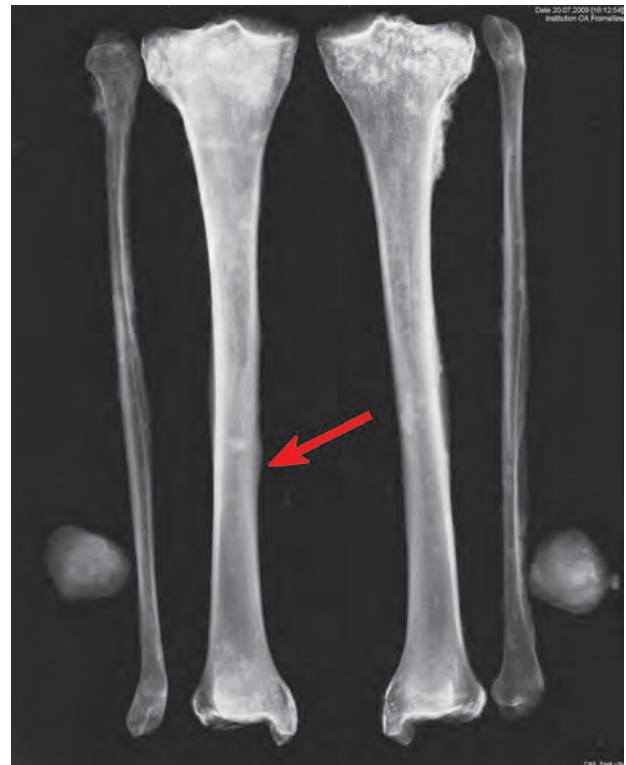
Radiograph showing right and left lower limb bones (1667B); the right tibia has an area of increased density (arrowed)
